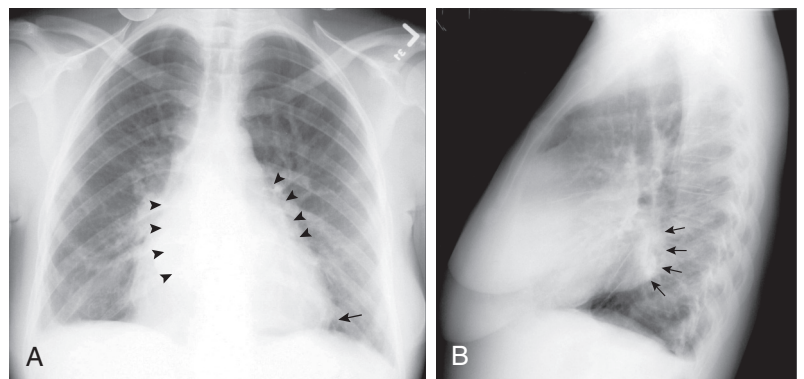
Chest radiographs of a 60-year-old woman with severe mitral stenosis. A, PA view showing enlargement of the left atrium (arrowheads), prominence of the hilar vessels, and pulmonary vascular redistribution. The transverse angle of the apex suggests RV enlargement (arrow). B, Lateral view confirming RV enlargement with filling in of the retrosternal airspace. Note also the marked LA enlargement (arrows).
